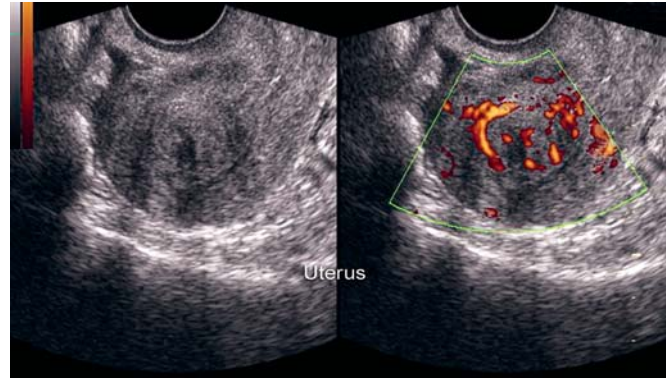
Focal subendometrial lesion. Differentiating this adenomyoma from a fibroid is possible with power Doppler studies. These reveal central vascularity with a spoke wheel radial pattern characteristic of an adenomyoma. Fibroids usually show only peripheral flow. Central flow in a fibroid is usually secondary to degeneration
